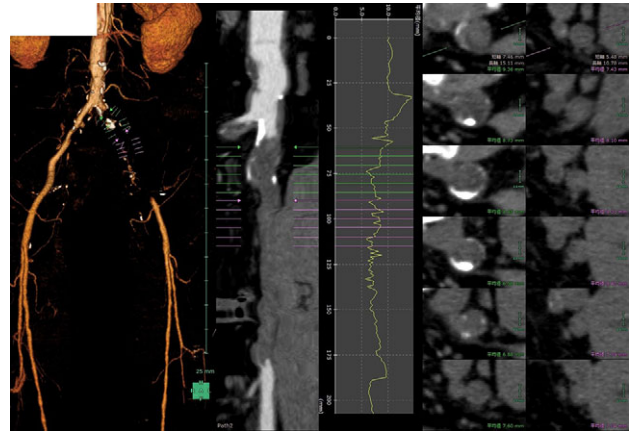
Postoperative 3D-contrast enhanced CT revealed the complete obstruction of left common iliac artery (CIA). The sagittal section through the left iliac artery and the graph of left CIA's internal diameter showed significant stenosis.
